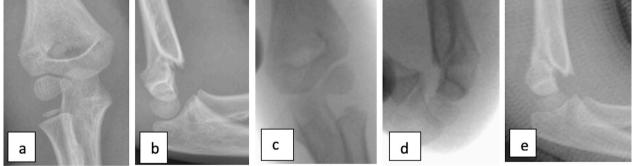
(a, b) Pre-operative AP and lateral radiograph showing Gartland type IIB fracture. (c, d) Intraoperative AP and lateral radiograph showing adequate reduction (closed reduction and casting). (e) Lateral radiograph showing loss of reduction 3 weeks postoperatively
